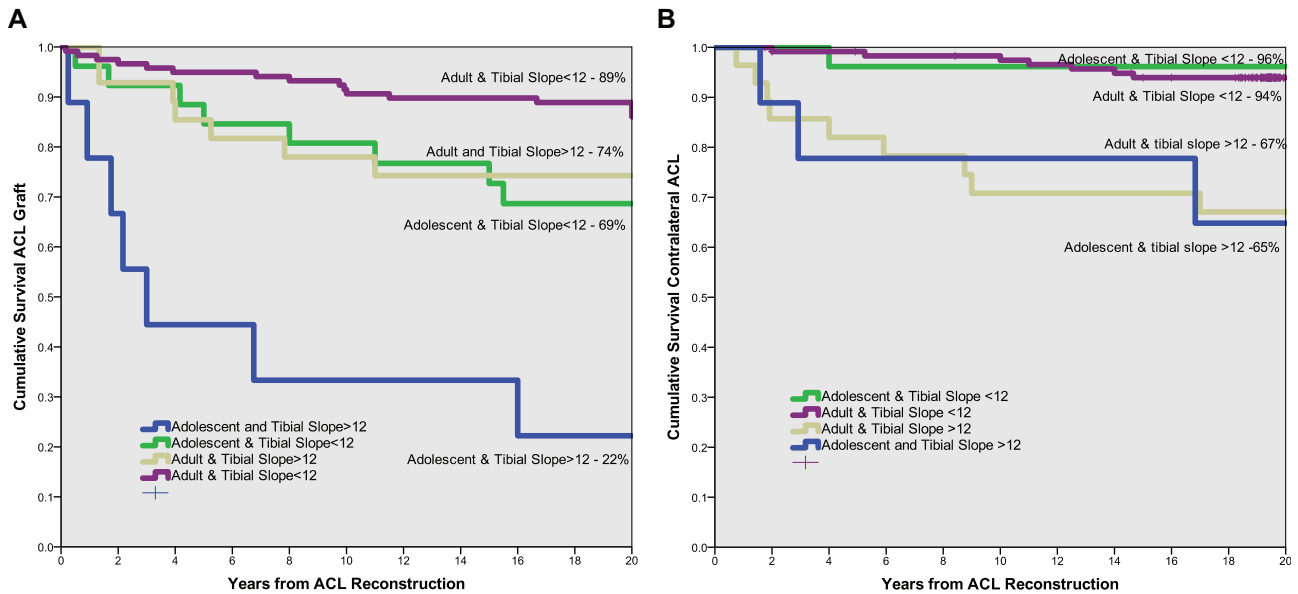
Cumulative survival of the reconstructed anterior cruciate ligament (ACL) and contralateral ACL according to radiographic sagittal tibial slope.
